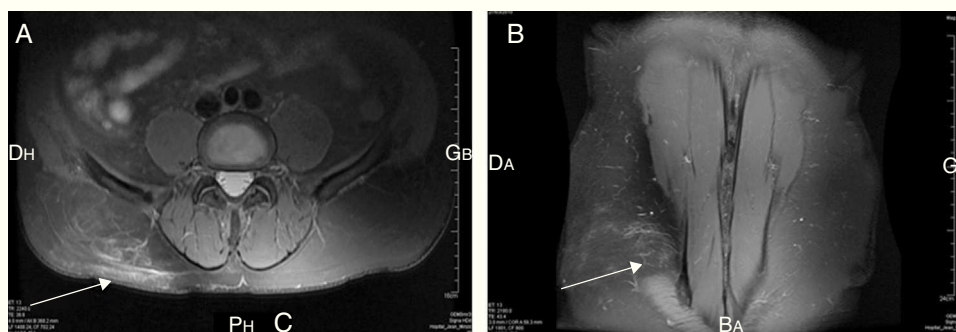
Axial and coronal planes of the patient's MRI, both showing T2-Fat saturation high signals in intramuscular structures. (A) Axial plane. (B) Coronal plane.
